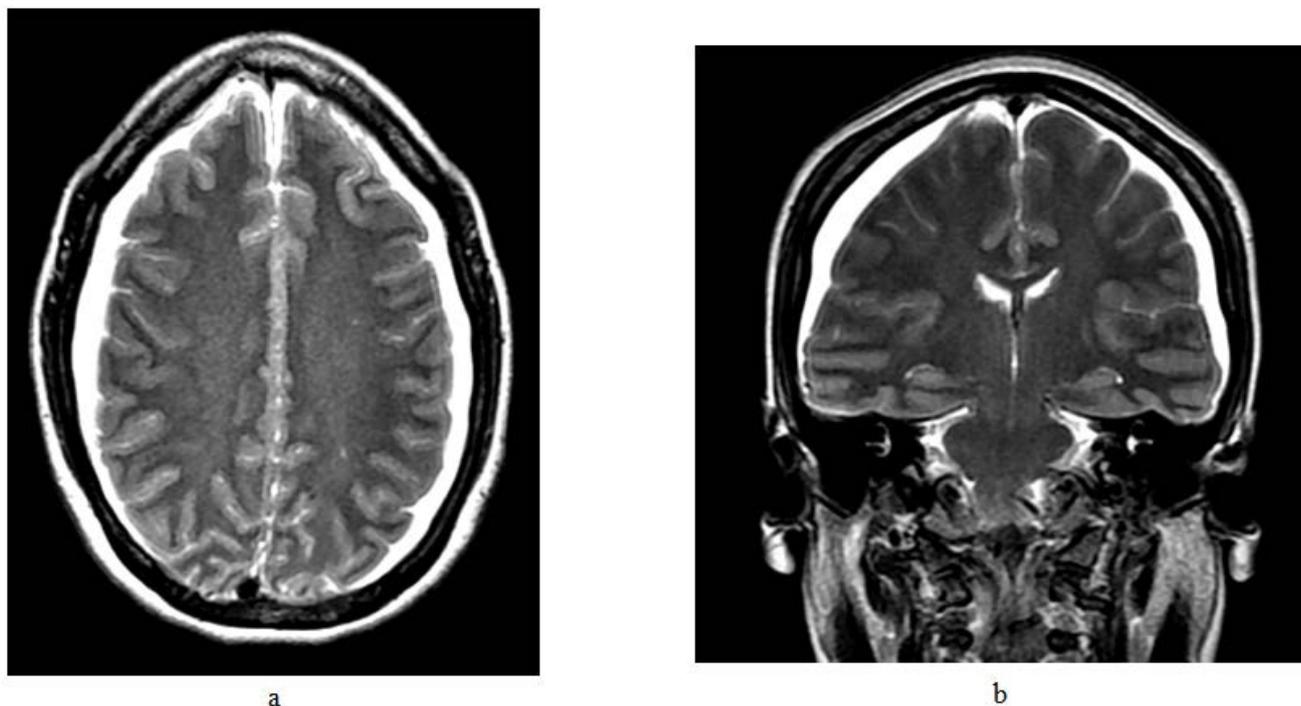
T2 weighted MRI of the brain showing bilateral fluid collections with flattening of both hemispheres. a) axial and b) coronal views
